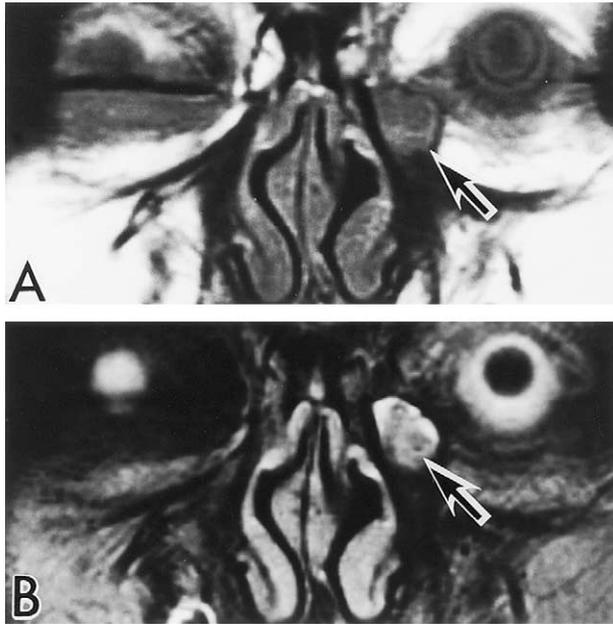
Magnetic resonance imaging coronal sections of a patient (case 12) treated by external dacryocystorhinostomy combined with mucosal grafting. (A) T₁-weighted image shows the superior two-thirds and inferior one-third of the left lacrimal sac to be hypointense and slightly hyperintense, respectively (arrow). (B) T₂-weighted image shows the left lacrimal sac to be heterogeneously mixed with hyperintense and isointense signals (arrow).
